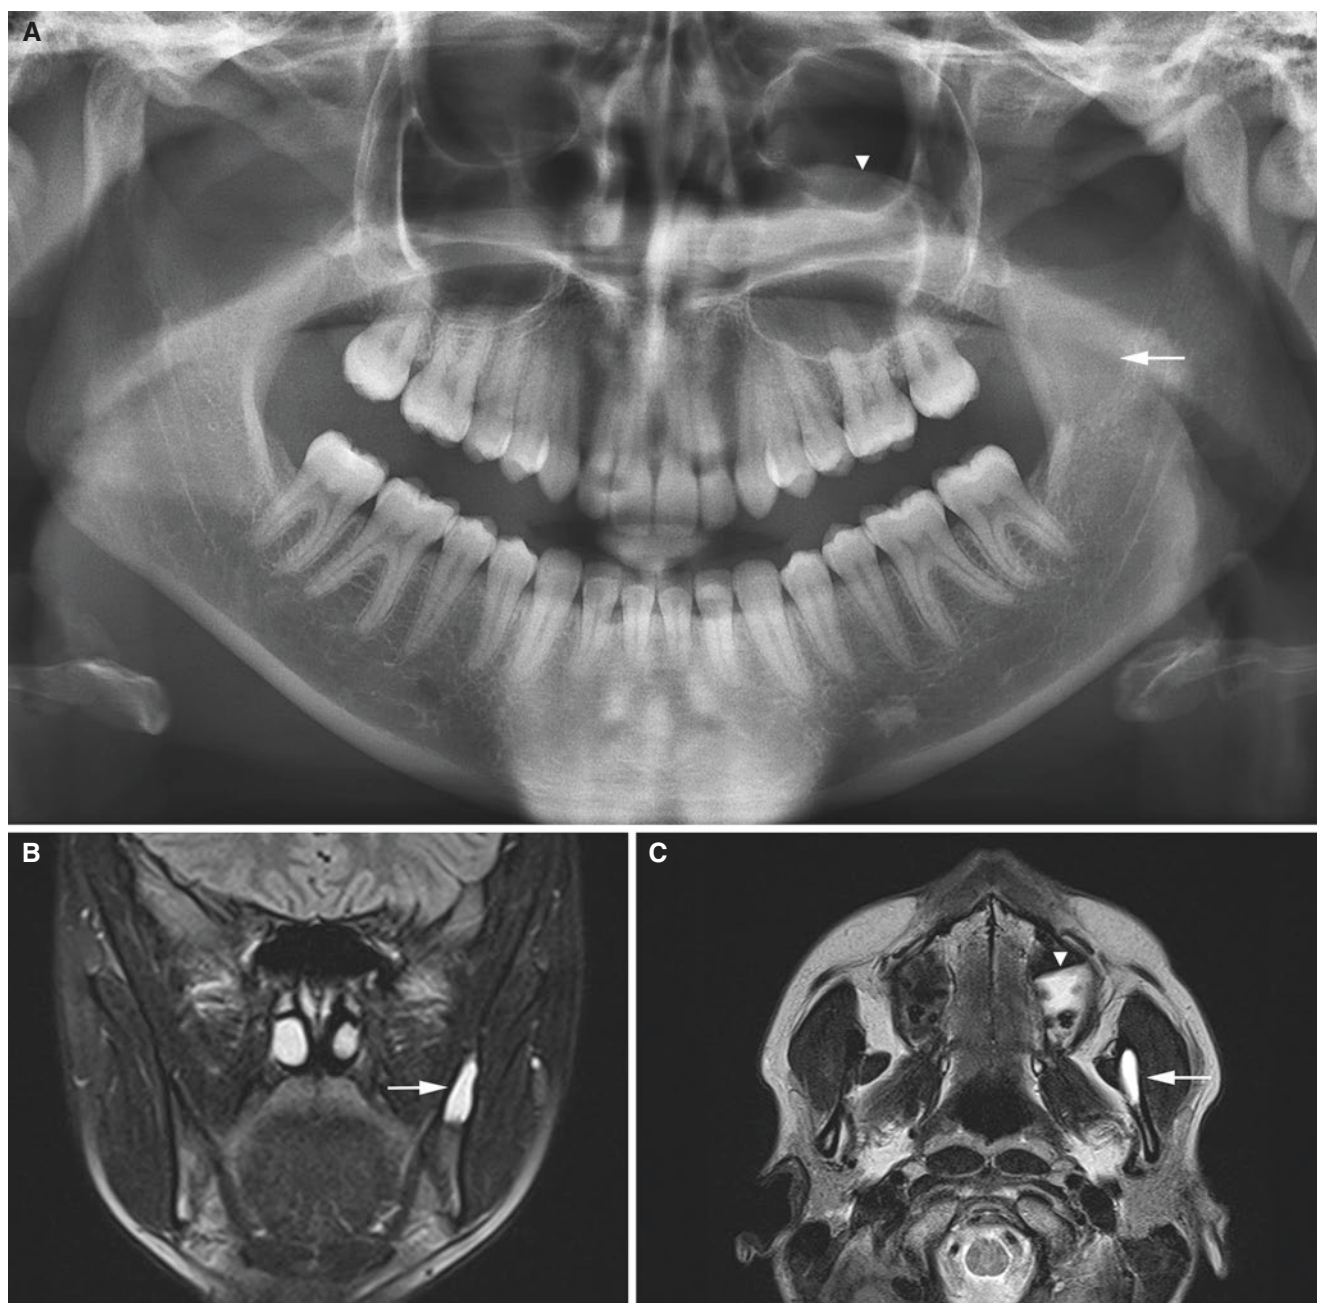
Simple bone cyst, mandible; 18-year-old female, incidental finding. (A) Panoramic view suggests radiolucency in left coronoid process (*arrow*). This examination was made after incidental finding in the mandible on cerebral MRI. Retention cyst in the left maxillary sinus
